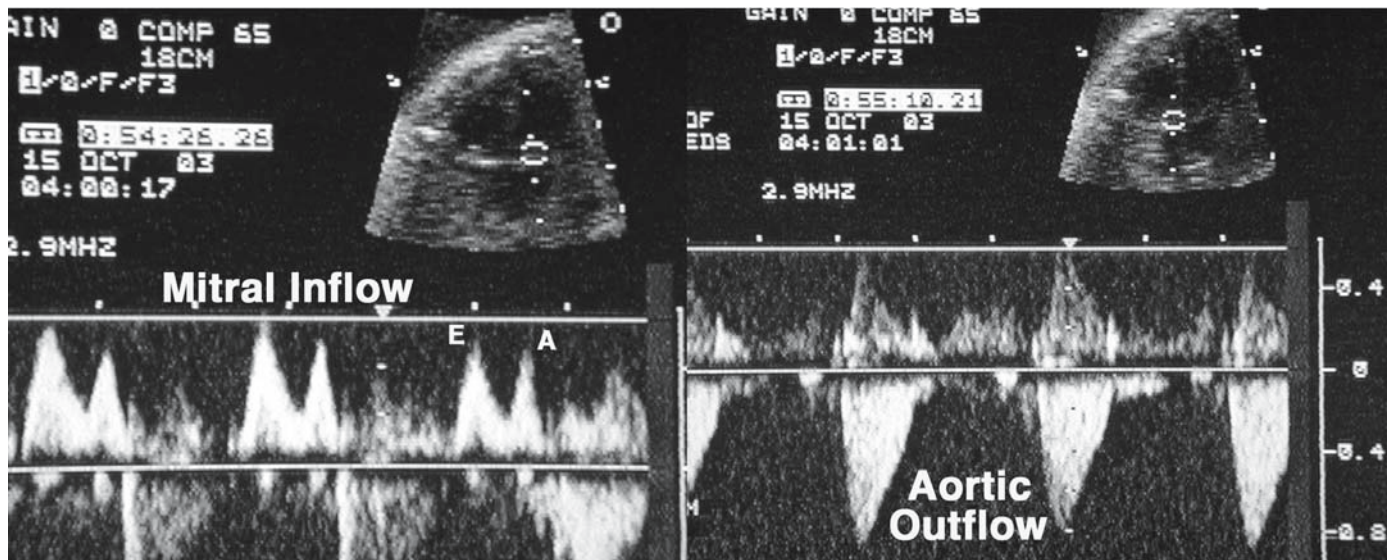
Fetal echocardiogram at approx 24 wk of gestation. Four-chamber views are shown with pulse wave Doppler analysis of mitral inflow and aortic outflow. Mitral inflow is characterized by two waves, an E wave representing passive filling of the left ventricle in diastole and an A wave representing active filling of the ventricle with atrial systole. Doppler flows are less than 1 m/s, indicating unobstructed blood flow, and the interval between aortic outflow signals is approx 0.5 s, indicating a fetal heart rate of 120 beats/min.
